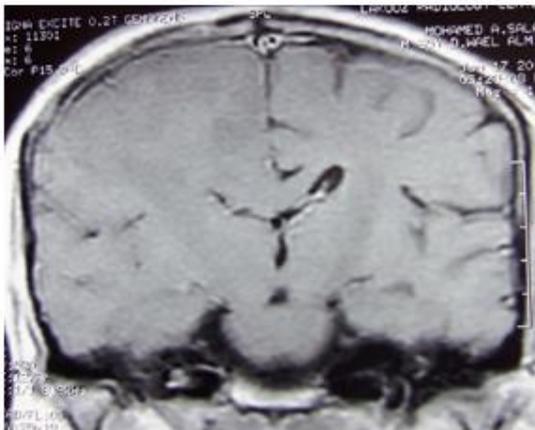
Postoperative T₁ MRI brain with contrast (total excision)
